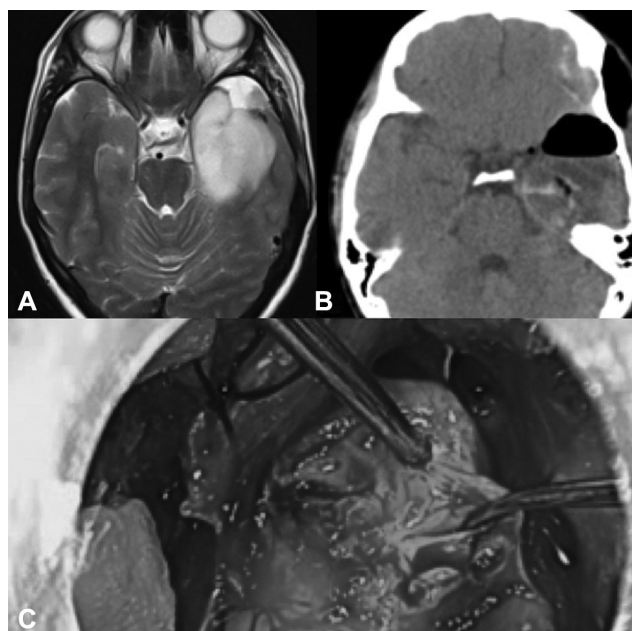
(A) Axial T2 weighted magnetic resonance imaging showing the heterogeneous hyperintense lesion in the anterior temporal lobe showing ill-defined margins. (B) Axial computed tomography image showing postoperative changes in the left temporal lobe and foci of air in the operative bed. (C) Intraoperative endoscopic view during tumor excision showing partly fibrous tumor.
